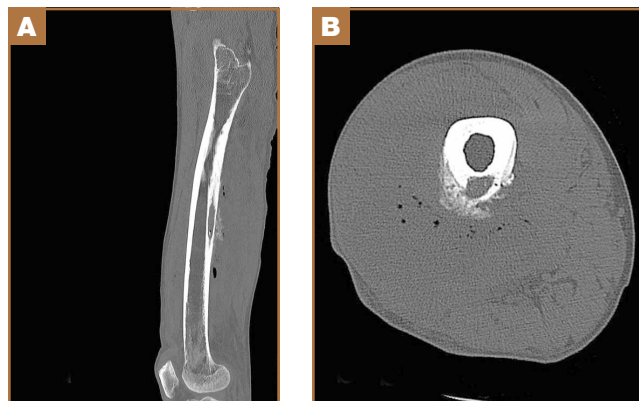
(A) Sagittal and (B) axial computed tomography views of the right femur show osteolytic lesion with demarcated sclerotic changes.
